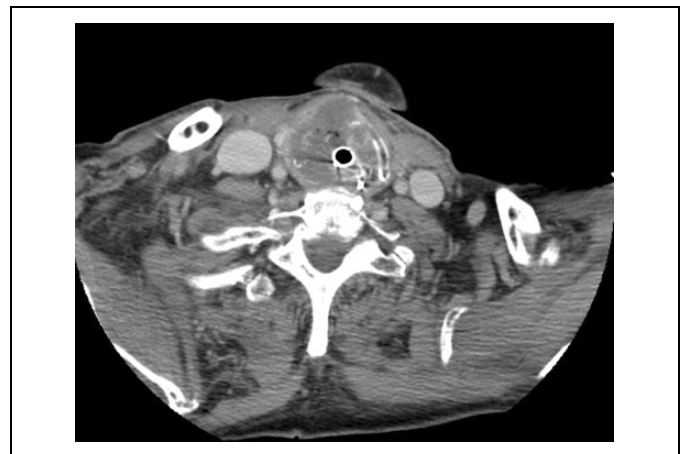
Computed tomography image showing an almost complete erosion of the laryngeal framework cartilages due to LMS. Residual airway is minimal therefore an emergency oropharyngeal intubation is needed.
